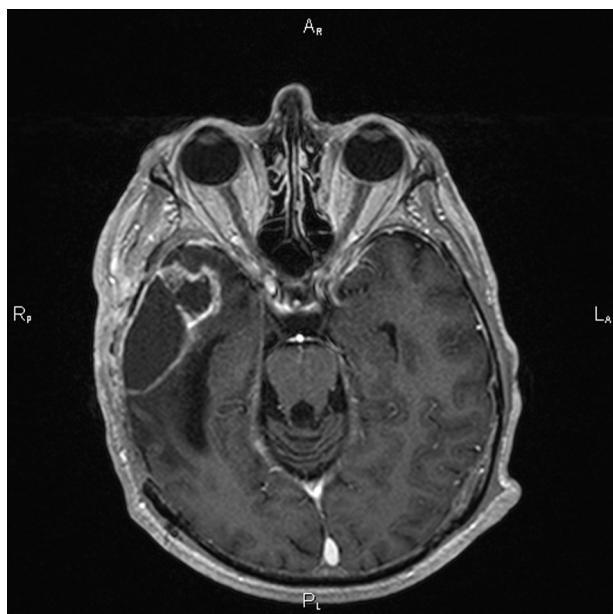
MRI scan after the second craniotomy.
